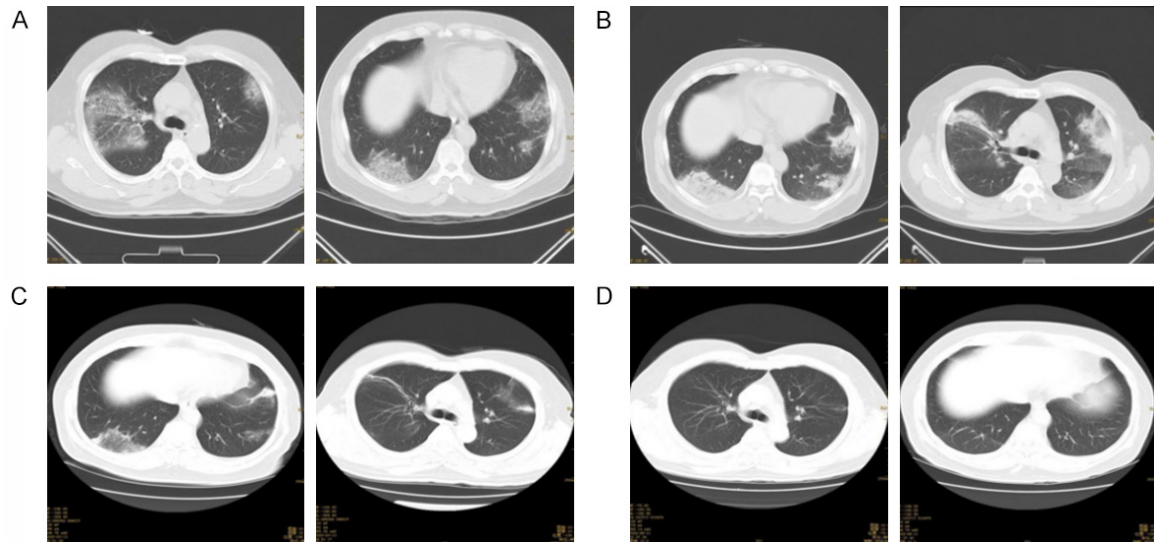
CT images of patient Mr. Lin (Male, Fifty-five years old) during different treatment periods. A: CT at admission (February 14, 2020); B: CT Reexamination after treatment (February 25, 2020); C: CT Reexamination after treatment (March 13, 2020); D: CT Reexamination after discharge (June 11, 2020).
